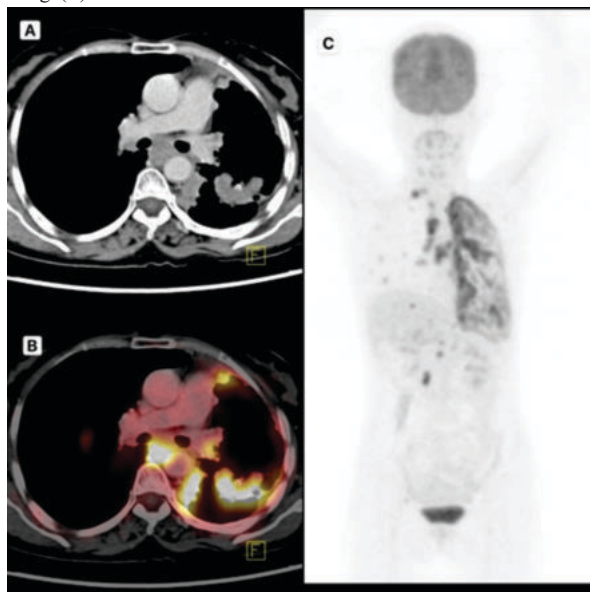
48-year-old female with ALK rearranged stage IV lung Adenocarcinoma. CT and PET images show a 3.3 x 3.5 cm lesion in left lower lobe (A, B) with pSUVmax = 9.2 and mediastinal nodes with nSUVmax = 10.9.
